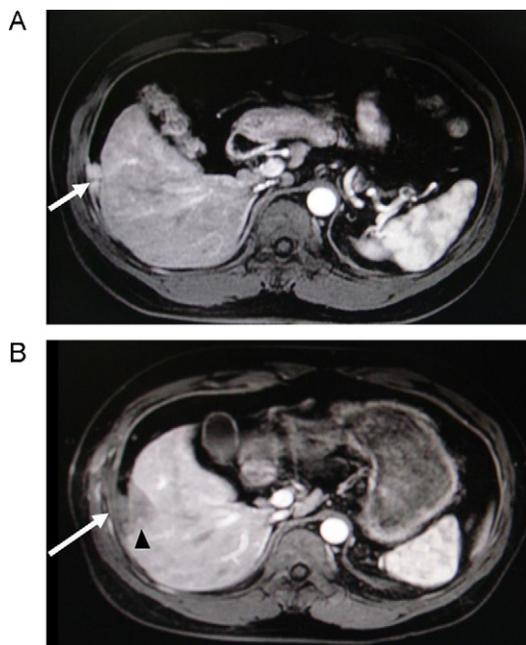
A 36-year-old man with needle tract seeding after percutaneous microwave ablation of subcapsular hepatocellular carcinoma, who was previously performed biopsy for three insertions. (A) Transverse contrast-enhanced MRI shows hyperintensity 20-mm diameter seeding nodule (arrow) at the external capsule of liver 11 months after MWA in arterial phase. (B) Contrast-enhanced MRI shows hypointensity MWA zone (arrow) for seeding lesion and part of liver tissue (arrowhead) in arterial phase.
